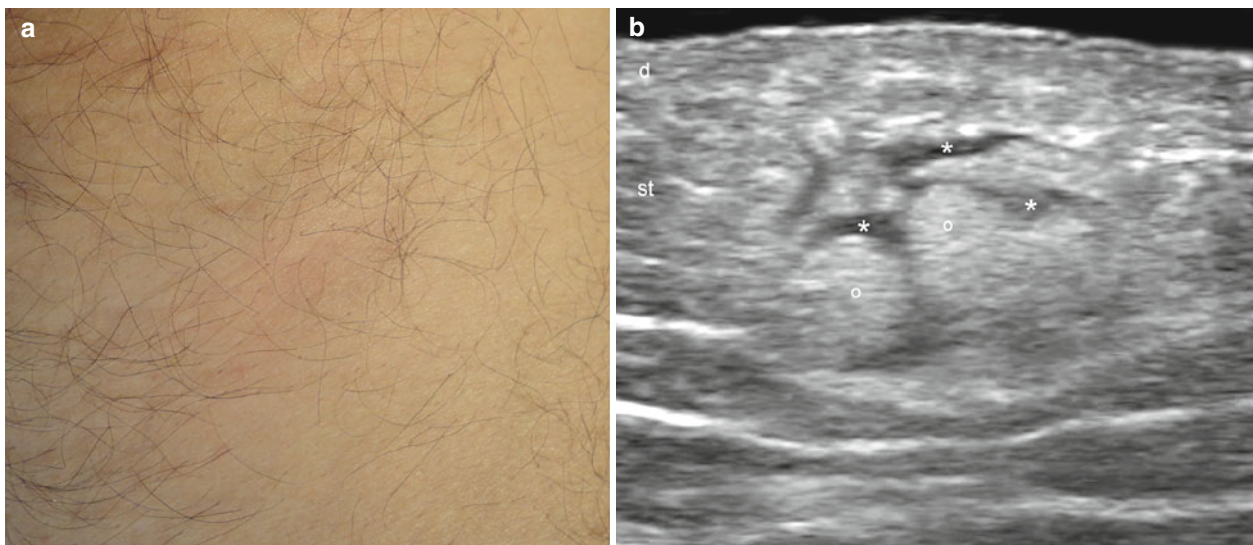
(a–e) Mostly septal panniculitis. (a) Clinical image shows slight erythema and induration. (b) Gray scale (longitudinal view) demonstrates focal increased echogenicity of the fatty lobules (o) of the subcutaneous tissue with prominent hypoechoic septa (*). (c) Color Doppler ultrasound image (longitudinal view) shows a thick vessel running
